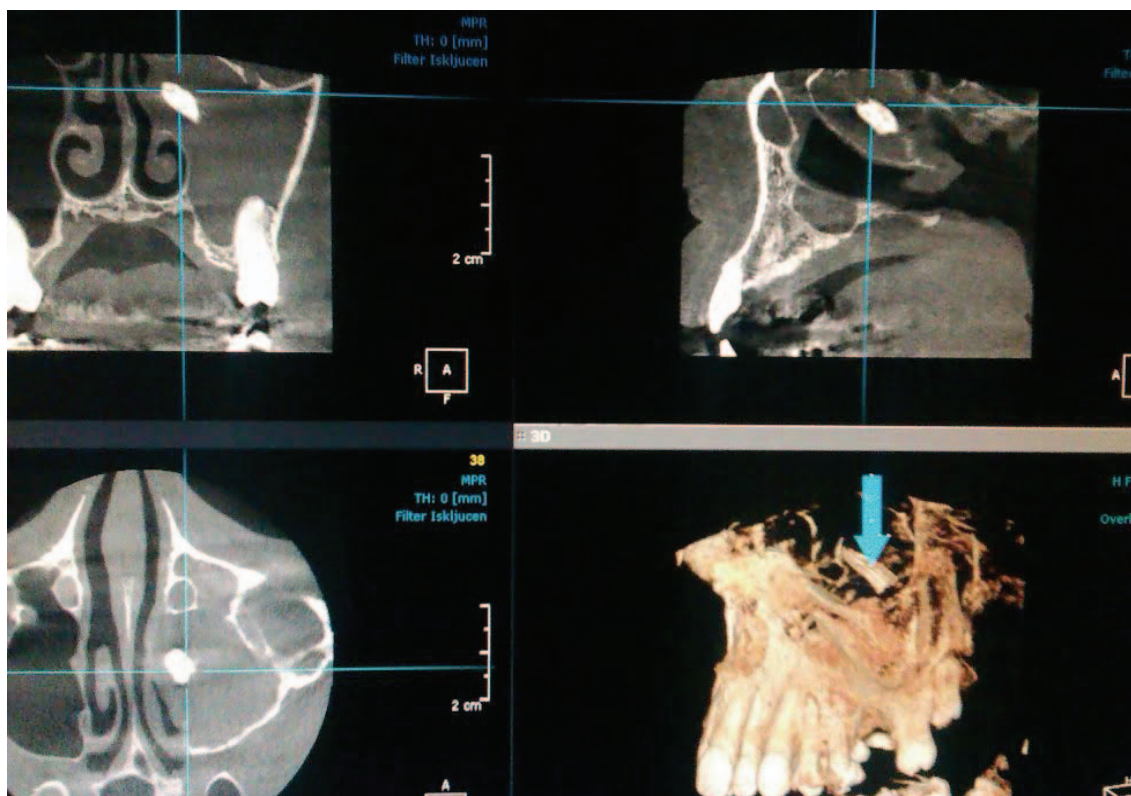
Cone-beam computed tomography (CBCT) of the paranasal sinuses shows the complete opacification of the left maxillary sinus. A foreign body, a part of tooth with intracanal filling, is seen in the area of osteomeatal complex (the second patient).
